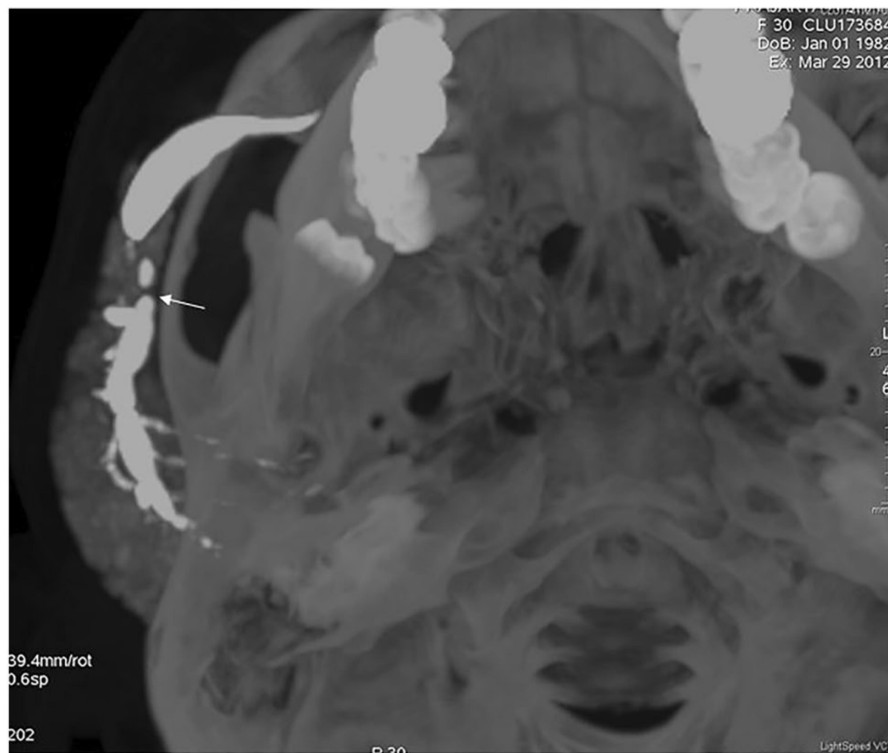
CT sialogram reveals stricture in right parotid duct which appears as filling defect and dilatation of duct distal to stricture
